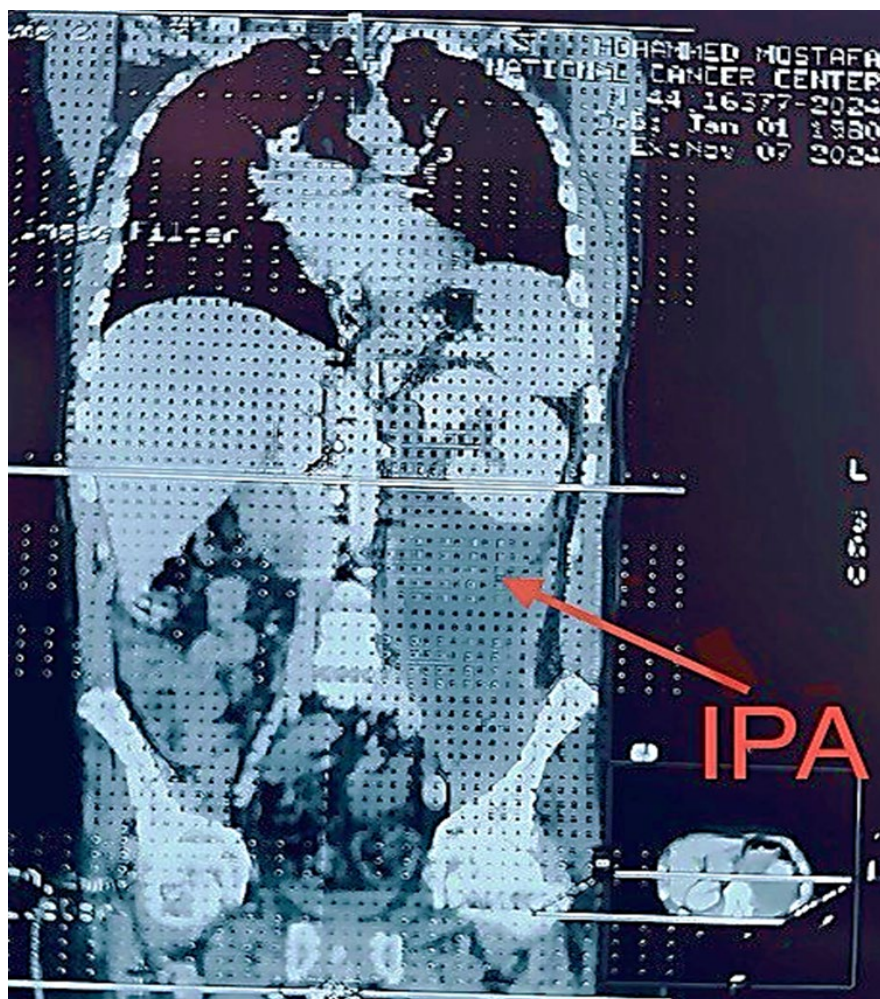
Axial CT scan of left iliopsoas abscess
